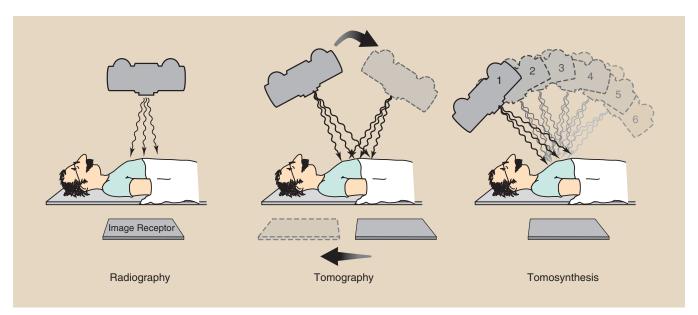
Equipment arrangement for obtaining a radiograph, a conventional tomography, and a digital radiographic tomosynthesis image set.
